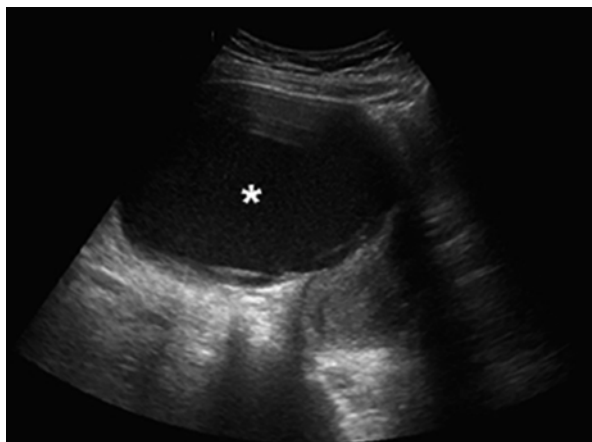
Endometrioma by ultrasound. Transvaginal ultrasound showing an ovarian endometrioma, indicated with an *asterisk* (\*)
